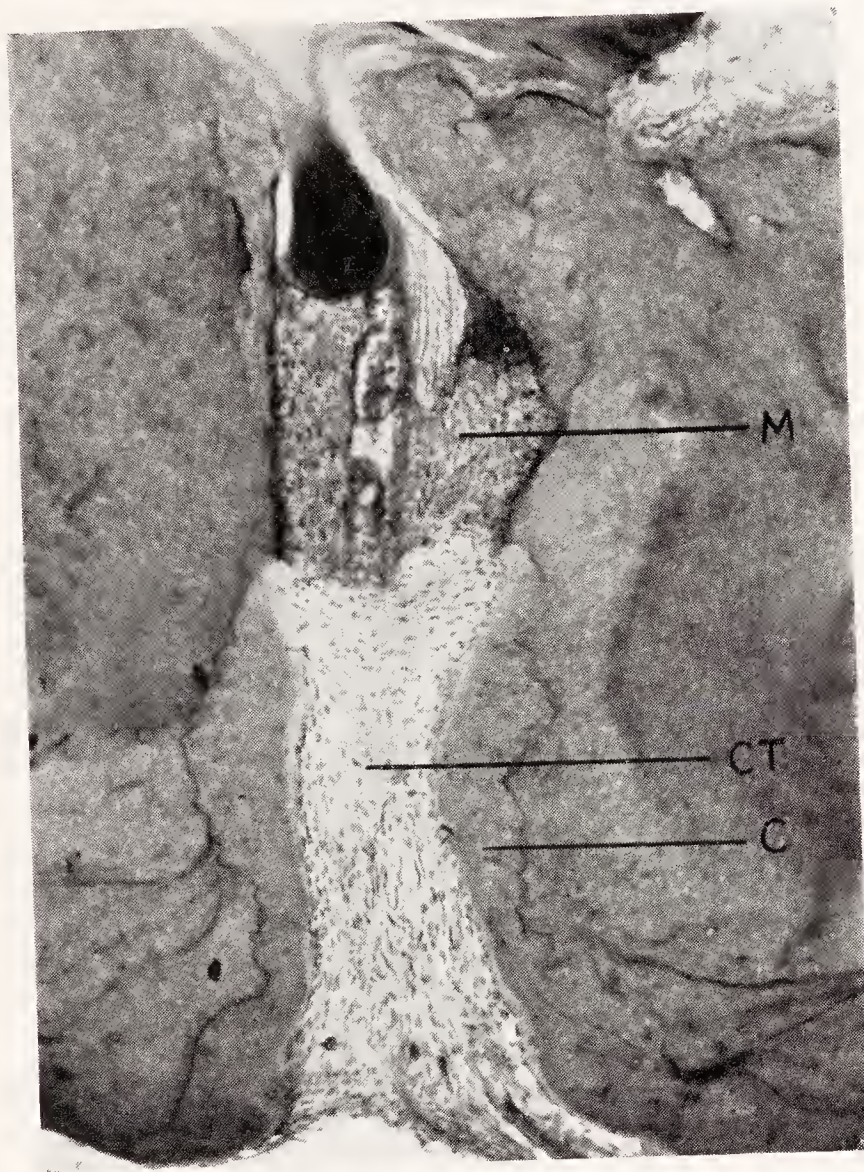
Root end of lower cuspid the pulp of which was devitalized by arsenic, amputated, and mummified with Gysi's Triopaste. *M*, mummified pulp tissue; *CT*, ingrowing periodontal connective tissue replacing the mummified pulp; *C*, cementum deposition along the walls of the root canal. (Courtesy of Joseph S. Rzeszotarski.)
